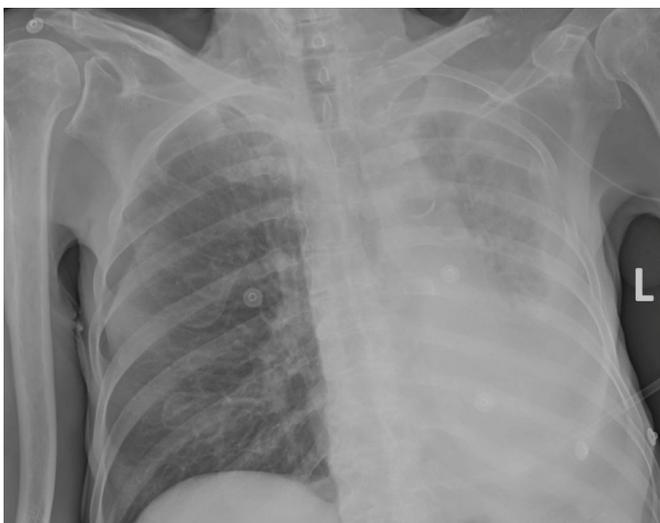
Chest radiography showed abnormal elevation of the left hemidiaphragm and reduced transparency of the corresponding lung due to possible atelectasis, with abundant pleural effusion on the left side.
